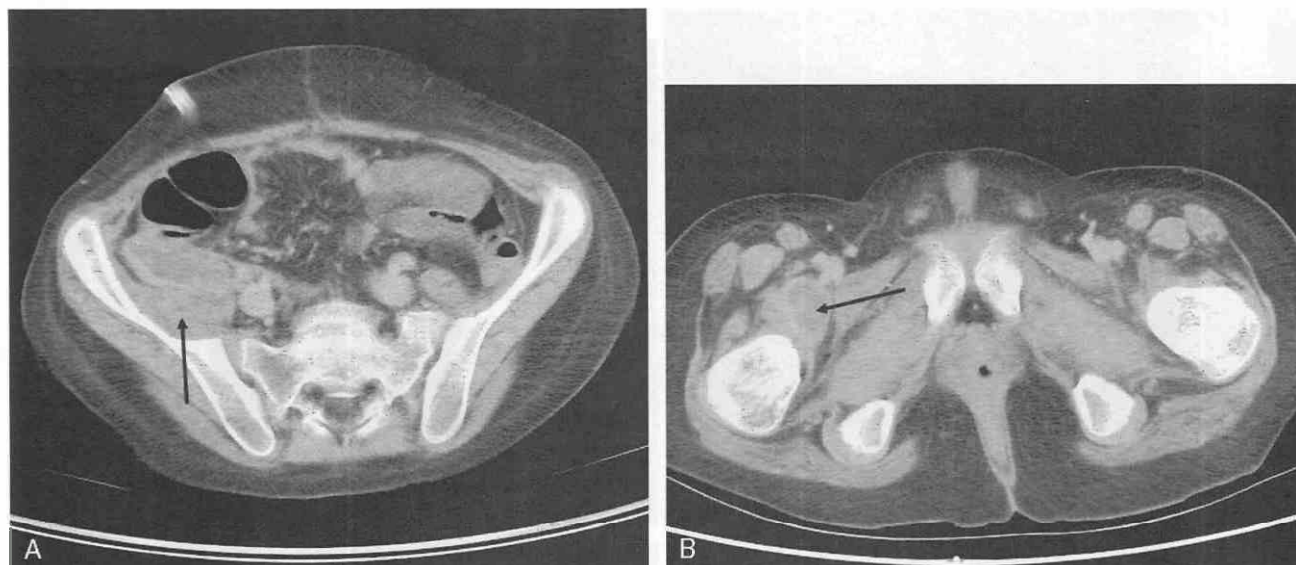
A, CT scan of a child with vasculitis and local perforation of bowel. A retroperitoneal abscess is seen in the right iliopsoas muscle (arrow). B, Abscess extends caudad through the psoas muscle and over the area of the lesser trochanter (arrow).
